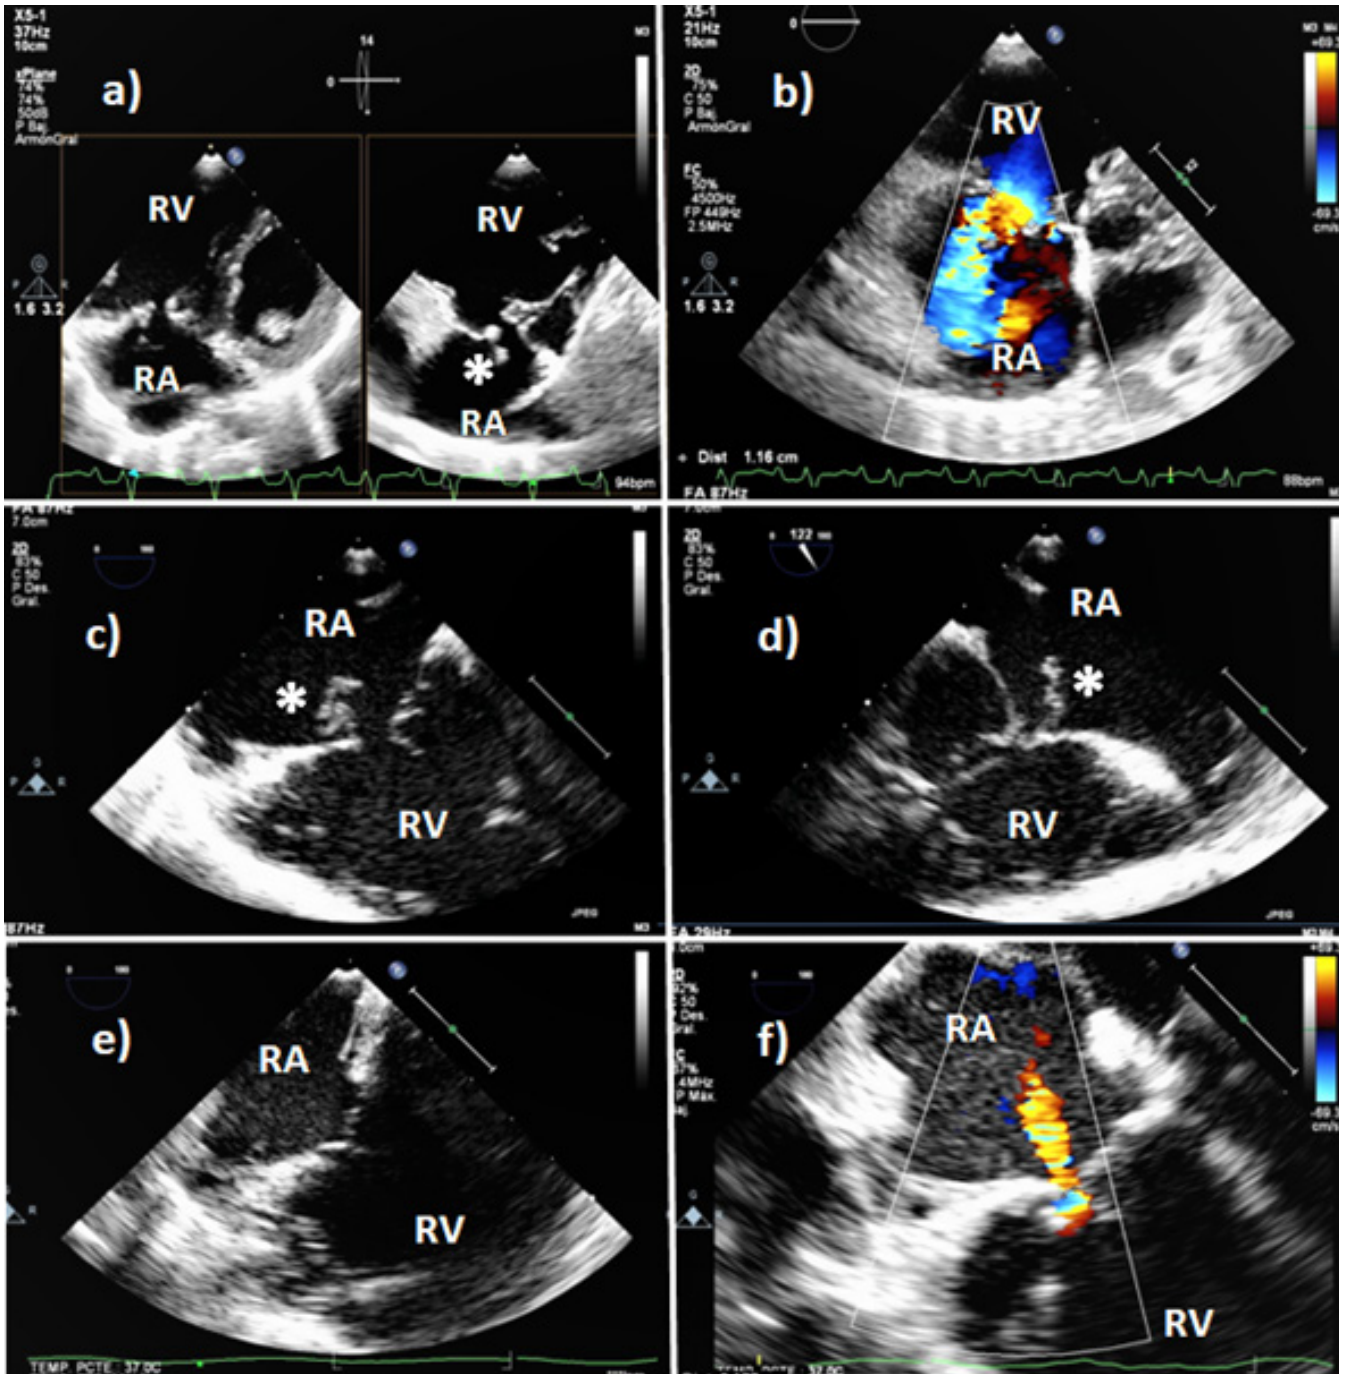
Transthoracic (a-b) and transesophageal echocardiogram (c-d) showed a flail of the anterior leaflet of the tricuspid valve (asterisk) with severe regurgitation and dilatation of the right ventricular cavities. Transesophageal postoperative images showing the normal alignment of the tricuspid valve and mild regurgitation (e-f). RV: right ventricle. RA: right atrium. LV: left ventricle. LA: left atrium.
